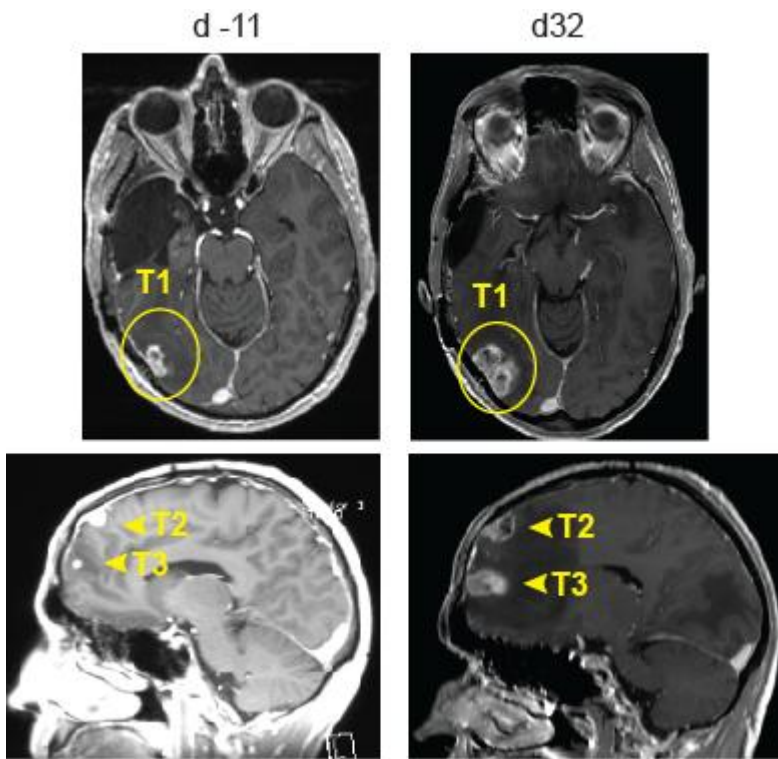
Evidence of rapid GBM progression prior to treatment on NCT02208362. Days of MRI are indicated relative to enrollment on this trial (d0). For reference, ICT Rickham catheter was implanted on d50.
